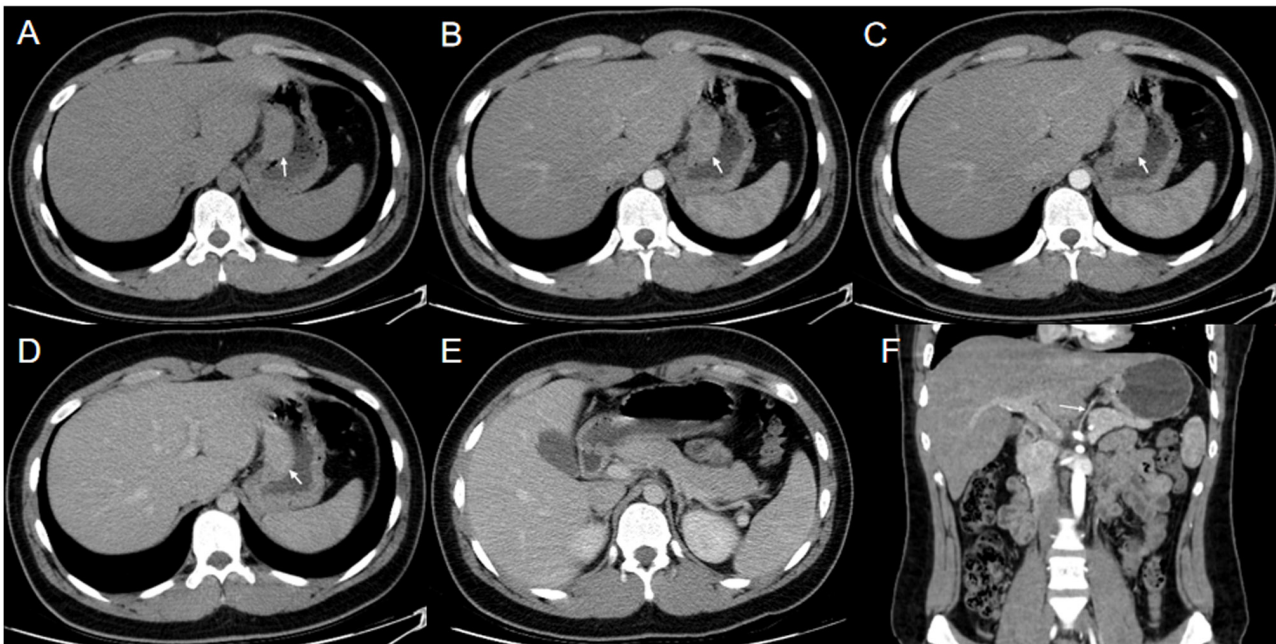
Computed tomography plain and enhanced imaging findings of the gastric lesser curvature mass. (A) Plain scan showing a soft-tissue mass in the gastric lesser curvature. (B) Mild enhancement in the arterial phase. (C) Enhancement in the portal venous phase. (D) Sustained enhancement in the delayed phase. (E) No mass in the gastric antrum level. (F) Coronal reconstruction showing the blood supply of the mass (white arrow).
